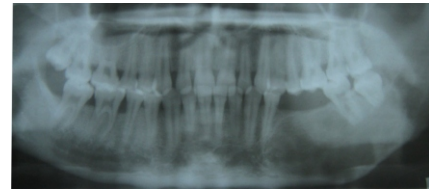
Orthopantomograph revealing radiolucency
